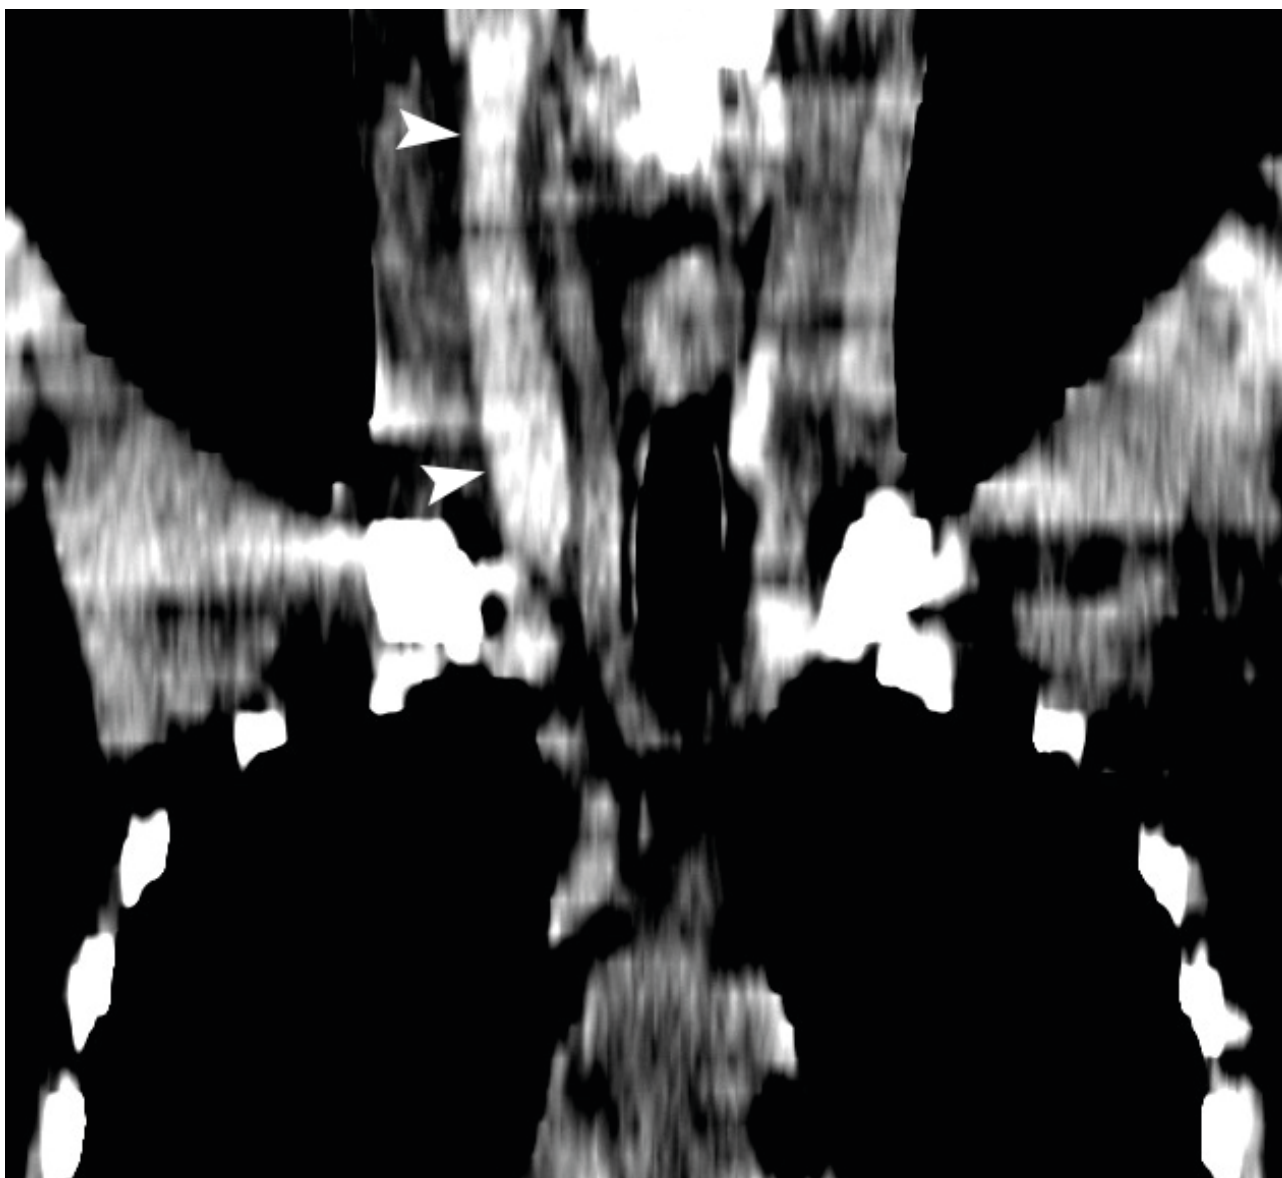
Non-contrast coronal CT scan (brain window) shows a thrombus (hyperattenuated) which filled the entire length of the dilated right internal jugular vein (*arrowheads*).
